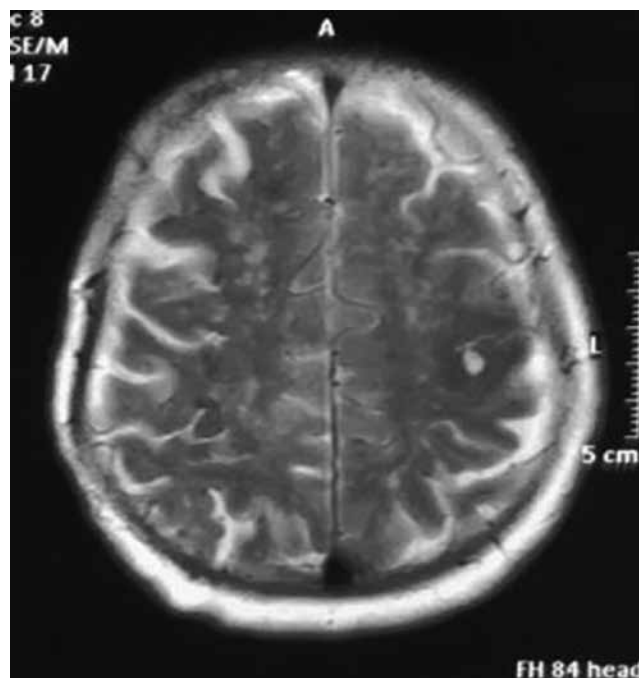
MRI brain axial view T2-weighted image showing left central sulcus hemorrhage.
